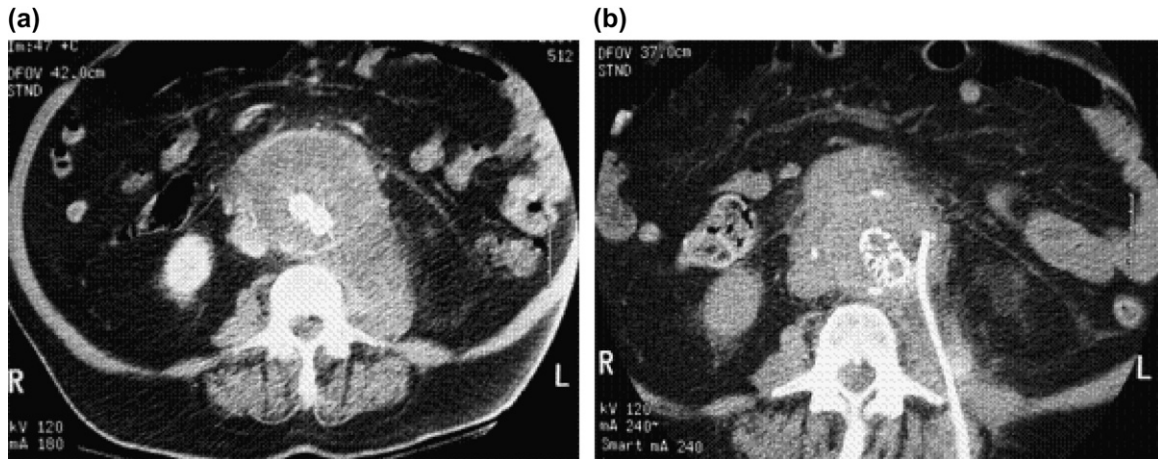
CT scan images showing aneurysm sac/psoas collection (a) and percutaneous drain (b). a) sac expansion & psoas collection b) percutaneous drainage.
